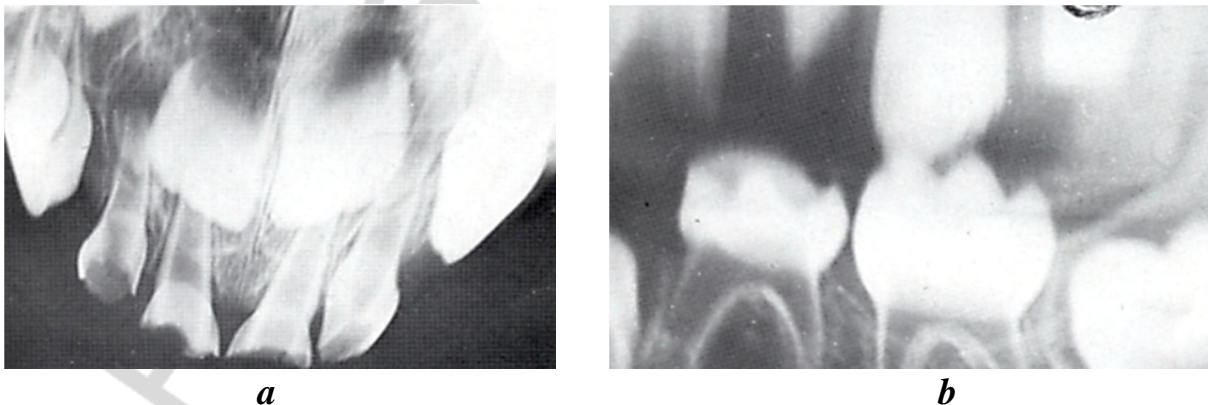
Coronal dentin dysplasia, X-ray picture:
